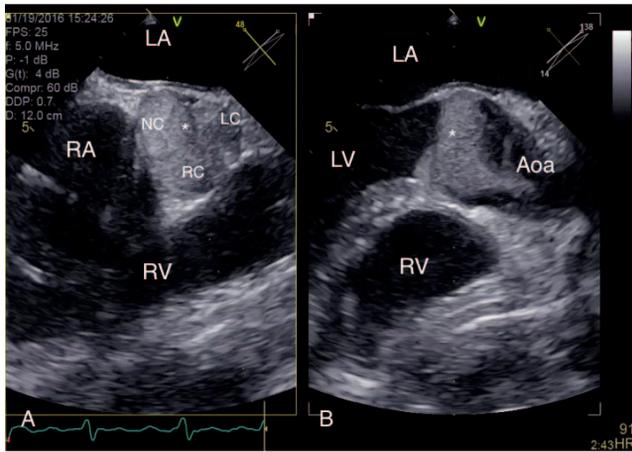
Transesophageal echocardiogram (A) aortic valve short-axis view and (B) long-axis view of the ascending aorta. In both views, the thrombus is identified by an asterisk. Aoa, ascending aorta; LA, left atrium; LC, left coronary cusp; LV, left ventricle; NC, noncoronary cusp; RA, right atrium; RC, right coronary cusp; RV, right ventricle.
